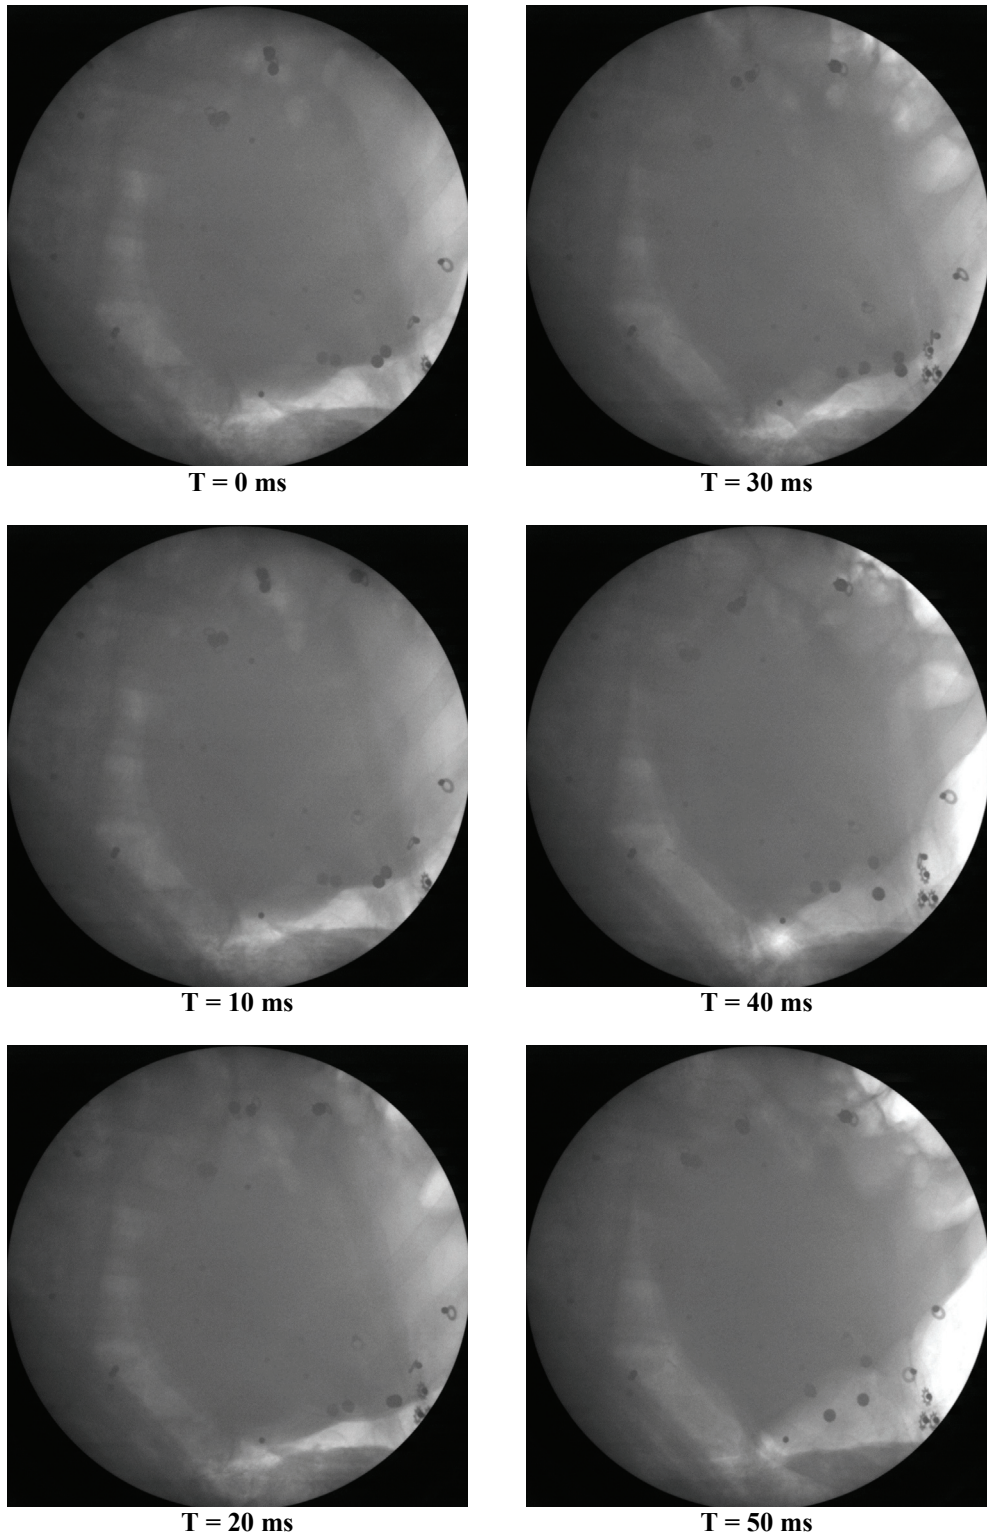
Example of a 4.0 m/s cylinder impact x-ray image sequence from SM72. §
